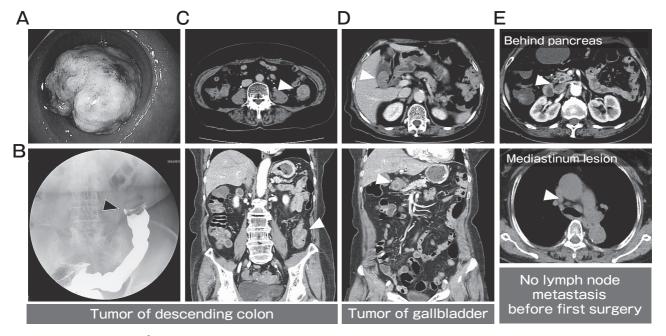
Clinical findings. A, Colonoscopy view of the descending colon showing the 5-cm mass with necrotic tissue at the surface, occluding the majority of the colonic lumen; B, Barium X-ray examination demonstrating the mass at descending colon occluding the majority of the colon (*arrowhead*); C, CT scan showing the 5-cm tumor at the descending colon (*arrowhead*). *Upper*: Vertical view. *Lower*: Sagittal view; D, CT scan showing the 4-cm tumor at the gallbladder (*arrowhead*). *Upper*: Vertical view. *Lower*: Sagittal view; E, CT scan showing that there is no remarkable lymph node behind the pancreas head (*upper*) and a small lymph node at the mediation before the first surgery (*lower*).
